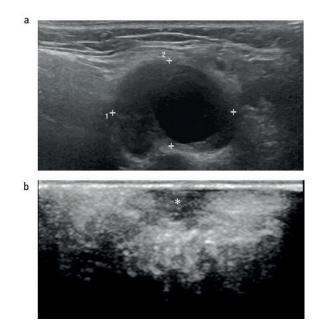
Use of ultrasound. (a) Ultrasound image of an enlarged neck node shows abnormal features with central necrosis and loss of normal fatty hilum. (b) Intra-oral ultrasound image depicts well a small tongue SCC (*) as a hypoechoic lesion. Size measurement and depth of invasion can be obtained
